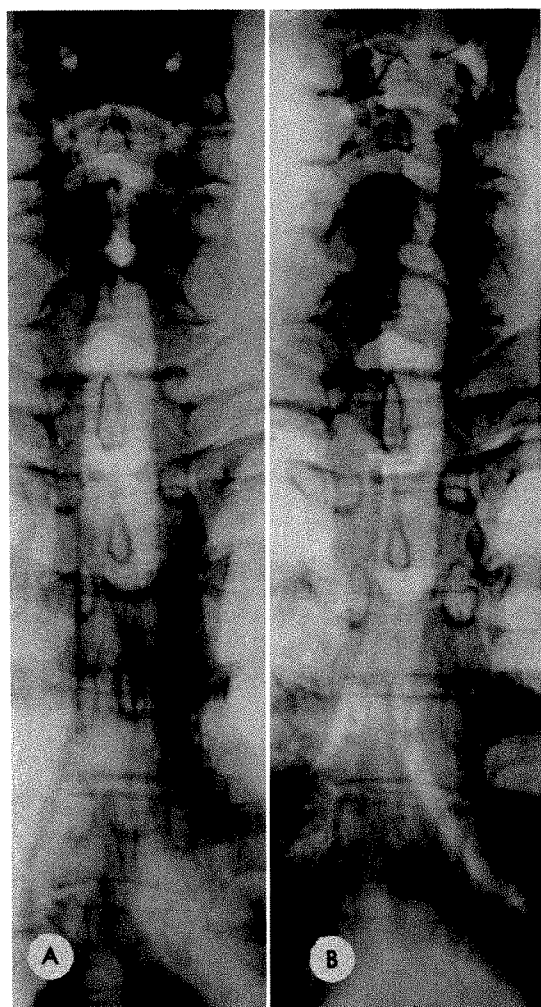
(A) Anteroposterior roentgenogram of a normal subject during respiratory arrest. (B) During "voluntary wheezing expiration" the trachea and main bronchi are narrowed; the trachea is shortened and the glottis is open.
